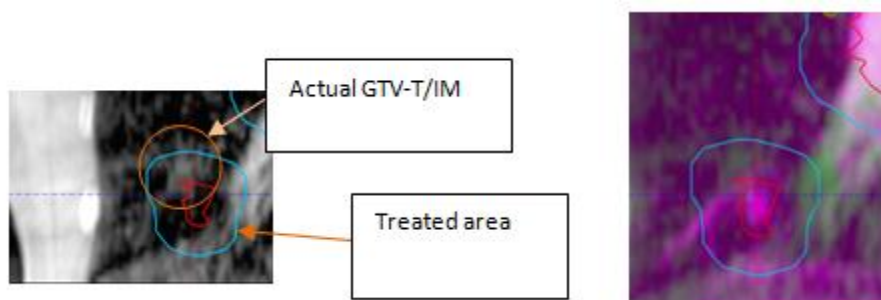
Left: actual GTV-T/IM position in fraction 1 for patient 18 after bony match. It can be seen that part of the GTV-T/IM is outside the treated area. Right: colored deviation of left image (frontal view). The large deviation in GTV-T/IM was seen for all CBCT for this patient when bony match was performed. This means that anatomical change in GTV-T/IM (tumor displacement) occurred and a rescan should be performed.
